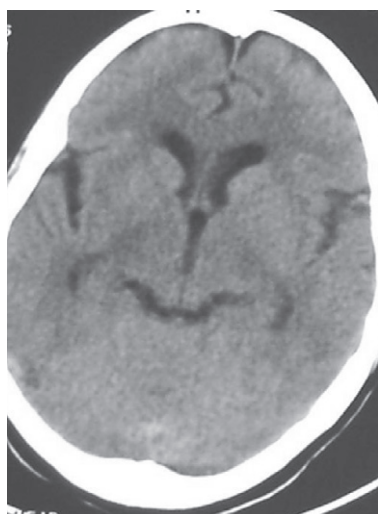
Non-contrast CT head showing resolution of sub-arachnoid blood before subjecting patient for intervention.
